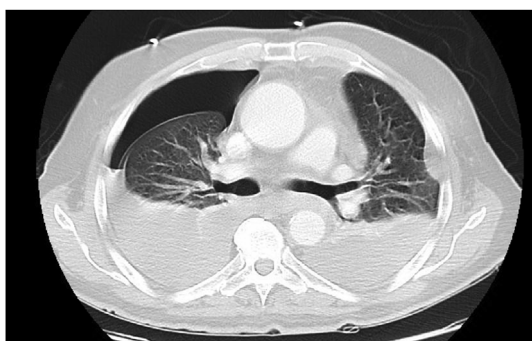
CT Chest sagittal view showing bilateral pleural effusions and right sided pneumothorax.
